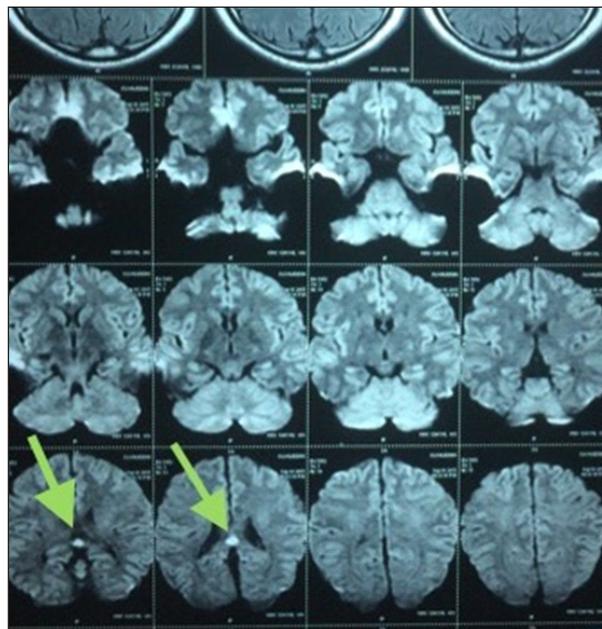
DW images on MRI showing hyperintense lesions at splenium of corpus callosum, reported as acute non-hemorrhagic infarct.
